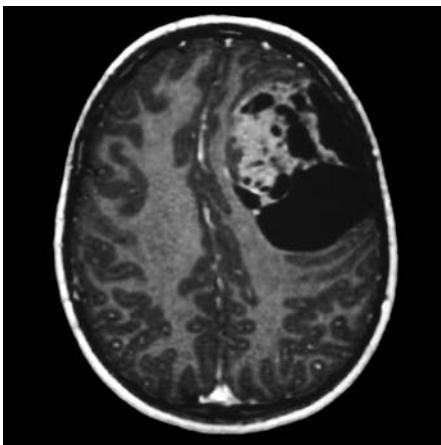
T1-weighted gadolinium-enhanced MRI of a cystic medulloepithelioma in the frontal lobe.
